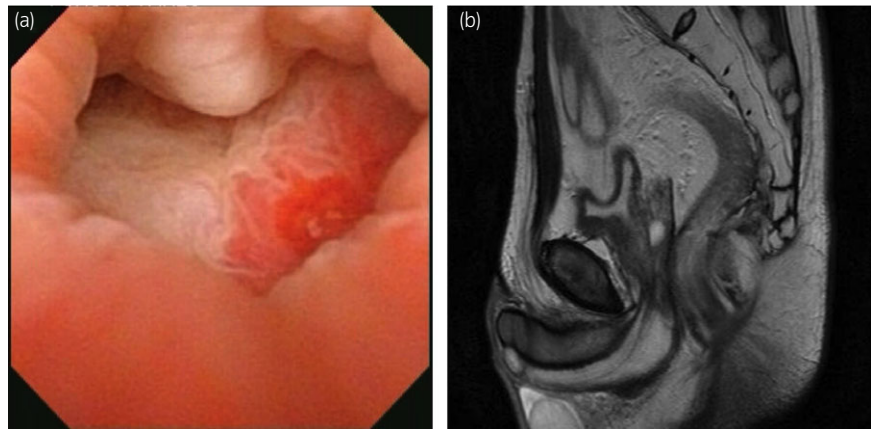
(a) Cystoscopic finding (patient h in Fig. 1) in the bladder lumen through the bladder neck from the prostatic urethra showed erythematous and hyperemic mucosa at the center of bladder posterior wall against the bladder neck. (b) MRI finding (patient h in Fig. 1) in the nearly empty bladder lumen revealed direct apposition of the flaccid posterior bladder wall against the bladder neck.
